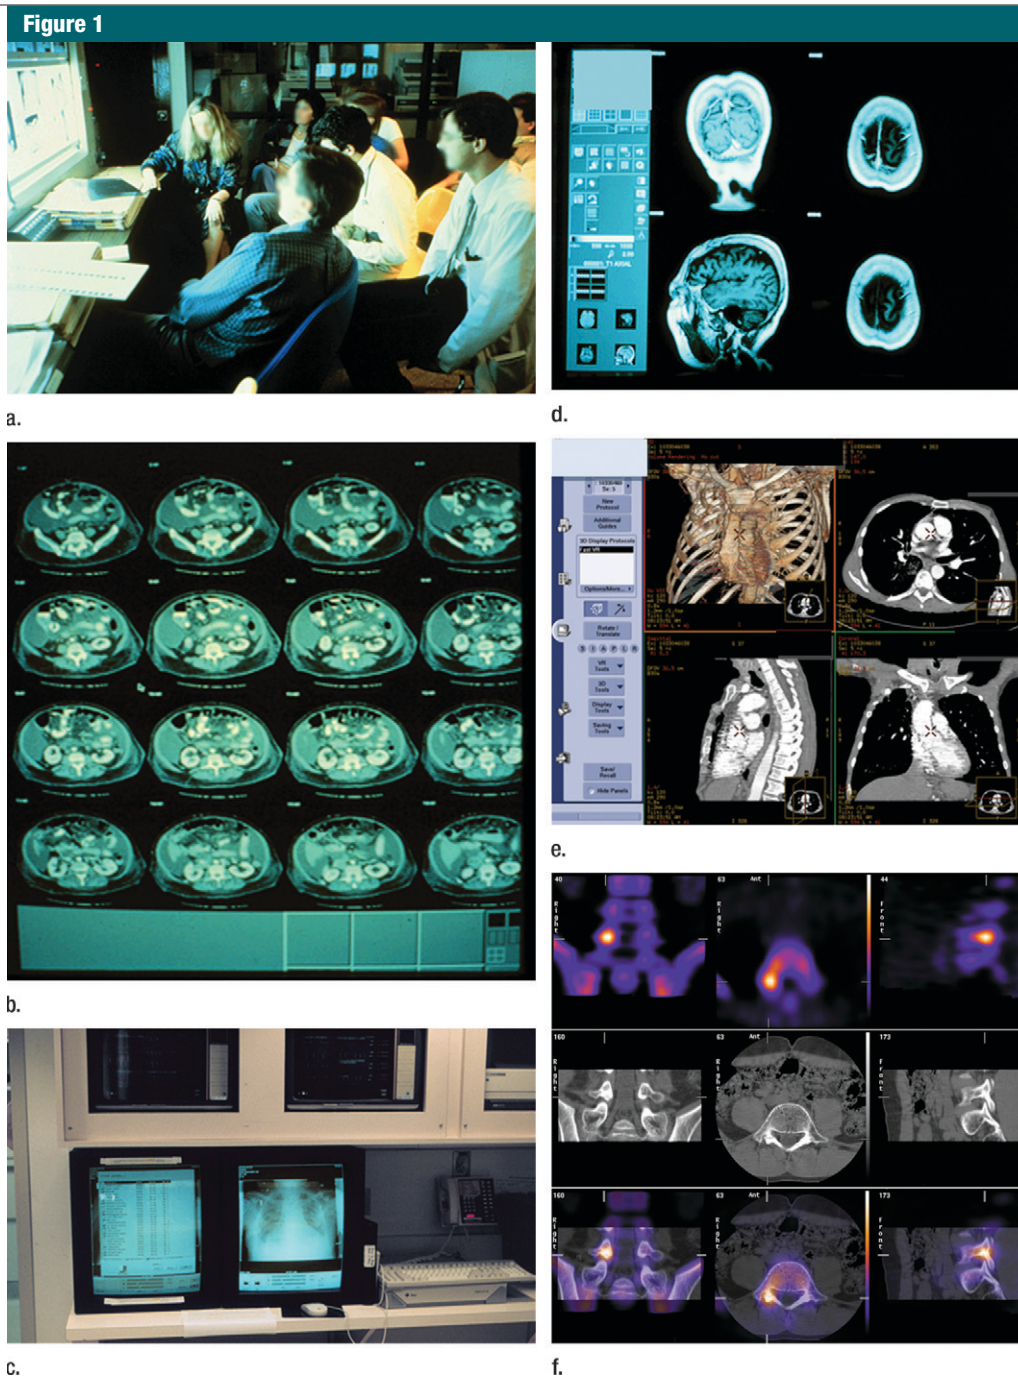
Evolution of radiologic imaging display paradigms. (a) Analog light box or alternator. (b) Analog view of digital modality (CT) using tile mode with one set window and level. (c) Simple picture archiving and communication system (PACS) workstation using digital display but largely static film paradigm. (d) Dynamic digital display paradigm with simultaneous stack or cine mode of images from multiple orthogonal MR sequences. (e) Advanced postprocessed 3D volume-rendered CT images with color and multiplanar reformations. (f) PET, CT, and fused PET/CT, from top row to bottom row, respectively.
